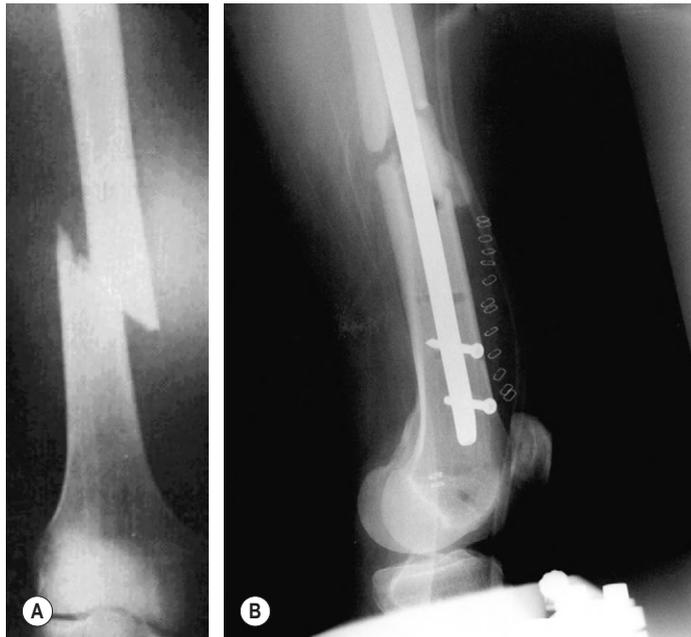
(a) The femoral fracture. Note that spasm in the quadriceps has resulted in overriding of the fracture fragments. (b) Note the locking screws and skin staples visible on X-ray.
